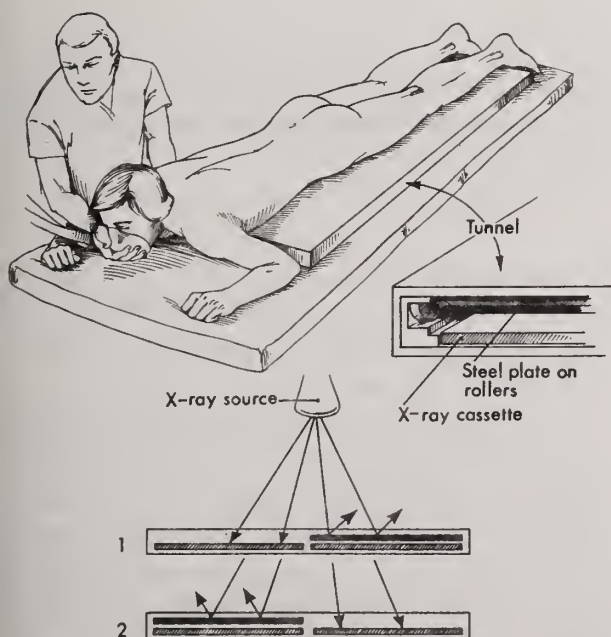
Translumbar aortography: The patient is prone, ventilated by mask. The x-ray table is constructed so that a movable steel plate covers one half of the x-ray cassette. By moving the steel plate the proximal and then distal portions of the x-ray cassette are exposed as the dye travels distally in the vascular system.
